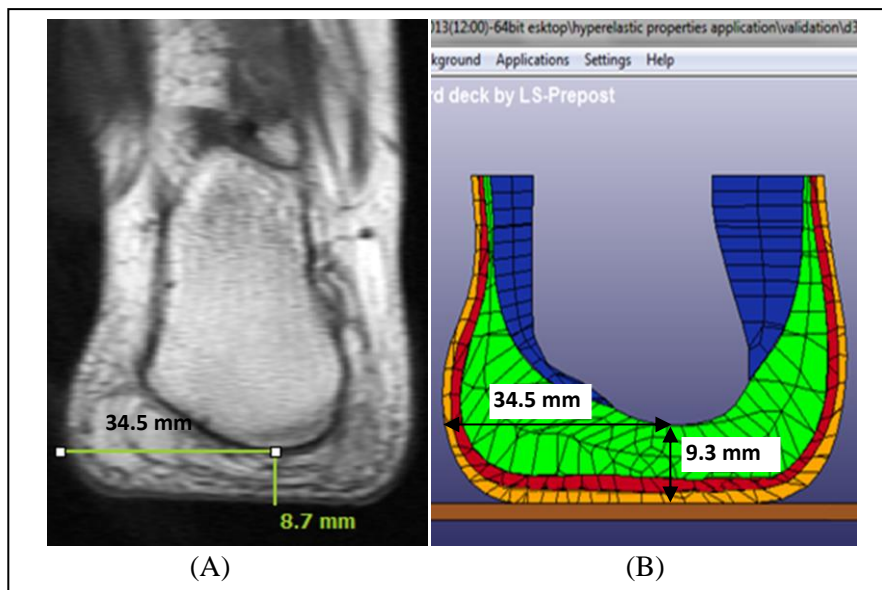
The loaded thickness of the heel pad subjected to a compressive load of 315.14N: (A) Loaded MR image of the heel pad; (B) FE model of the loaded heel pad.
